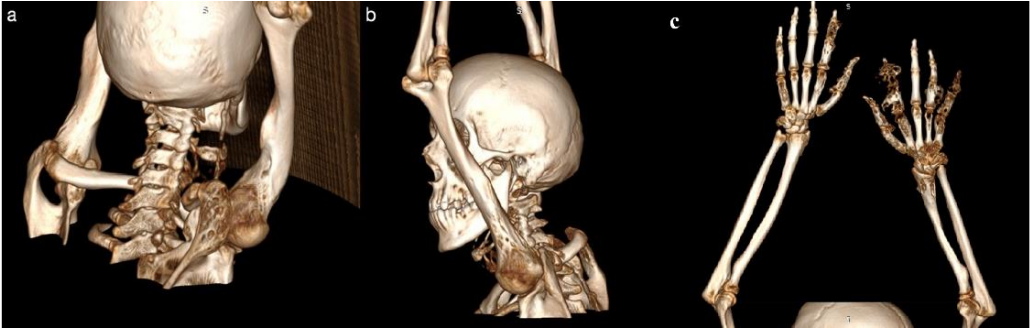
CT imaging. a, b. Enchondromas located in bilateral humerus and the left scapula.
